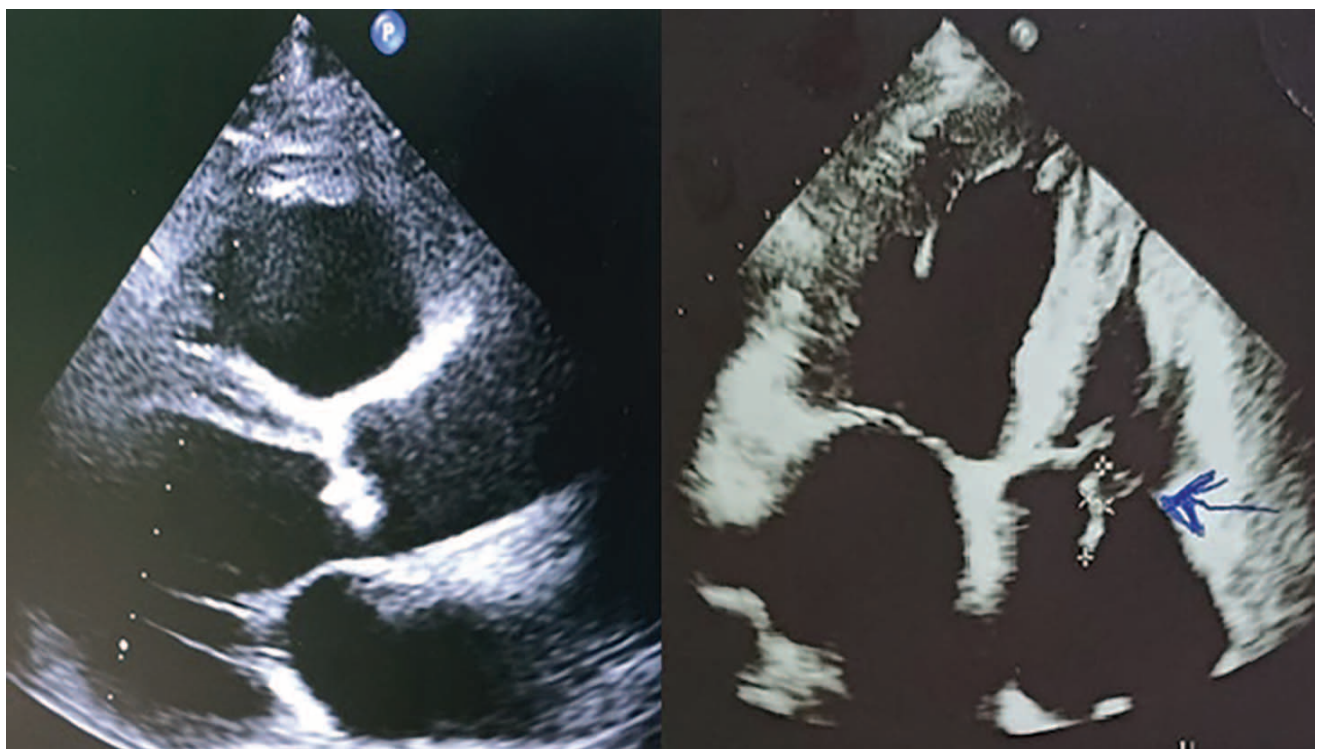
Subacute staphylococcal infective endocarditis of the native aortic and tricuspid valves in a 37-year-old female (left — parasternal long-axis view, PLAX; right — apical 4-chamber view, A4C).
